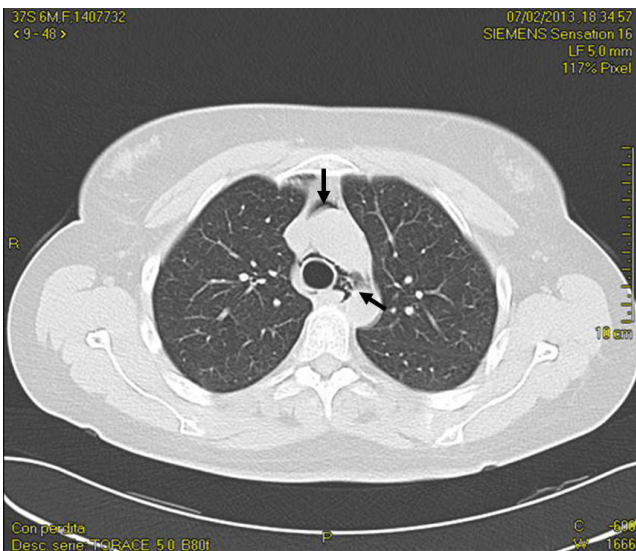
Computed tomography (CT) scan of the chest revealing pneumomediastinum
